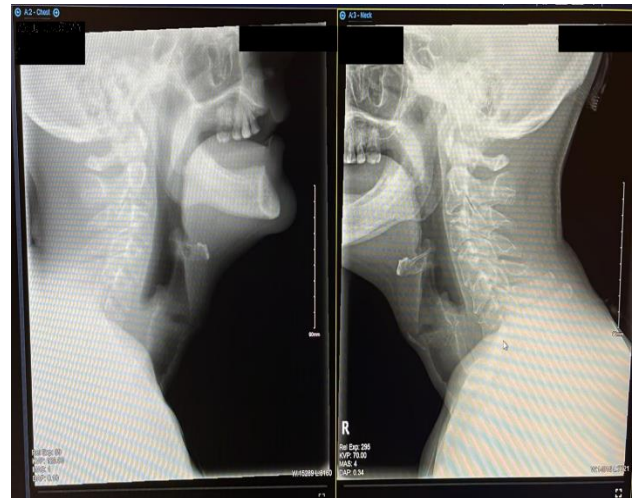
X-ray neck lateral view.
